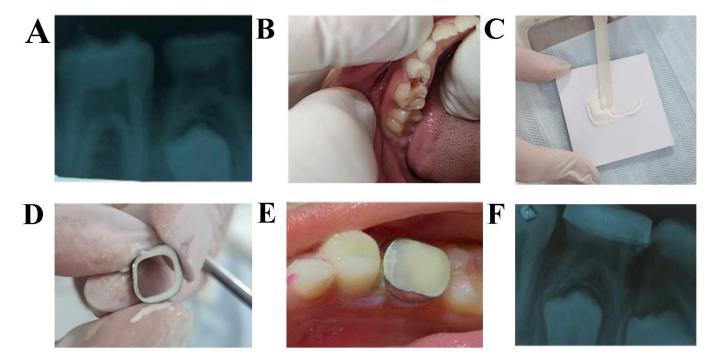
Clinical image sequence of orthodontic band installation (BGIC). (A) Initial radiograph of tooth 64. (B) Places caries lesion score 5 after prophylaxis. (C) Manipulation of the Ionomer. (D) Placement of the Ionomer in the orthodontic band. (E) Installation of the band on the tooth. (F) Radiograph after installation.
